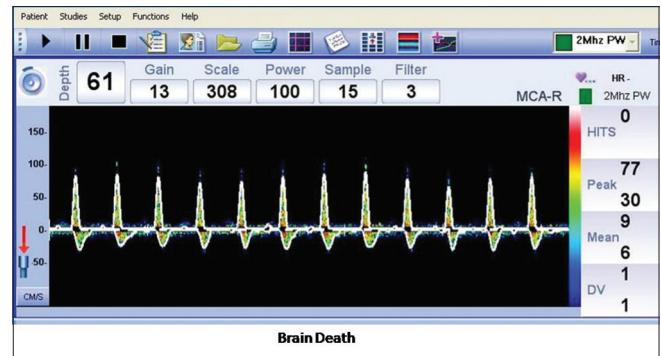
The transcranial Doppler waveform showing an oscillating or to and fro flow pattern, characteristic of brain death
